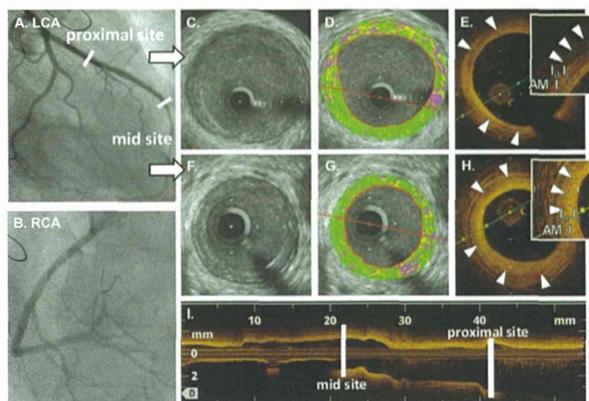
Coronary angiography images of left coronary artery (A) and right coronary artery (B); intravascular ultrasound images of the proximal (C) and the mid (F) sites of LAD; iMAP images of the proximal (D) and mid (G) sites of LAD; optimal coherence tomography images of the proximal (E) and mid (H) sites of LAD. Figure 1I shows longitudinal OCT image of LAD. A indicates adventitia; M, media; I, intima; I_d, donor-transmitted atherosclerosis; and I_c, intimal proliferation due to CAV. Arrowheads represent borderline between donor-transmitted atherosclerosis layer and intimal proliferation layer due to CAV.
